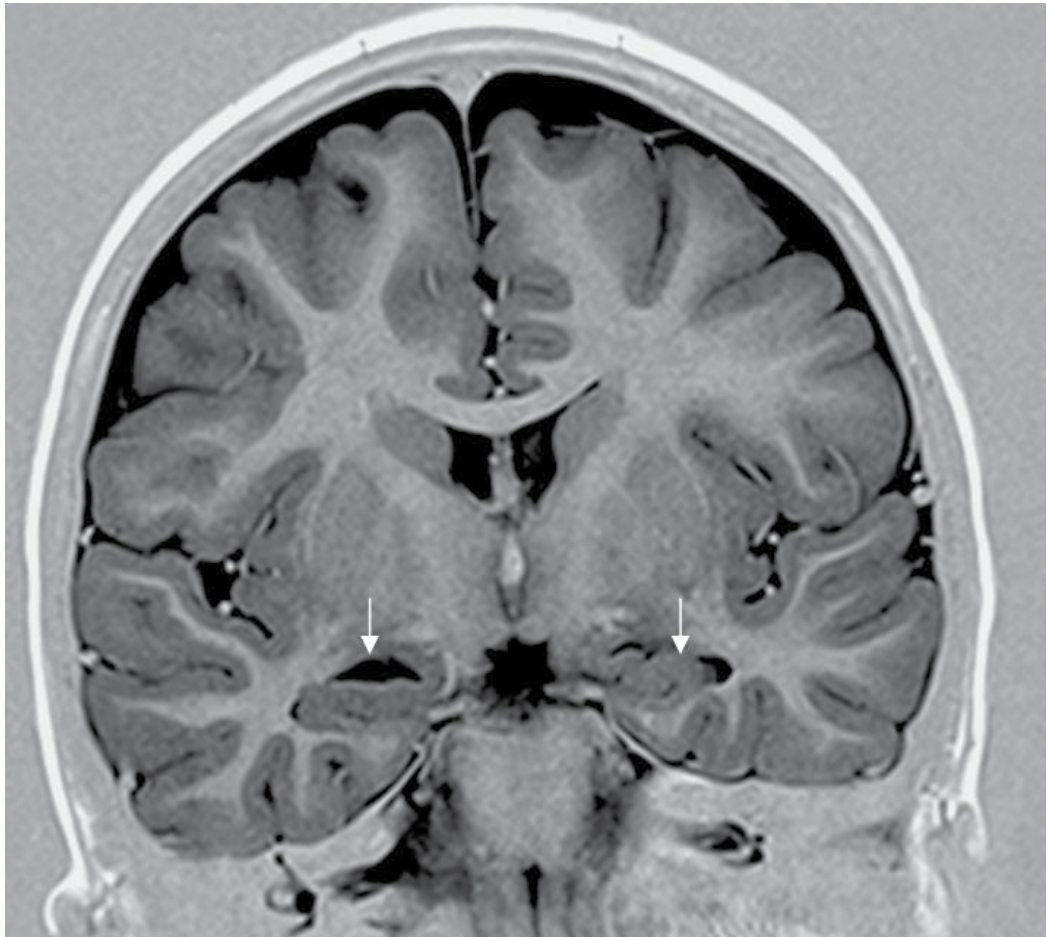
A male patient with mild mental retardation and temporal epilepsy (age: 29 years). Coronal T1W brain MRI-1.5 Tesla obtained by high-resolution. Asymmetry between choroid fissures can be seen clearly (arrows).
